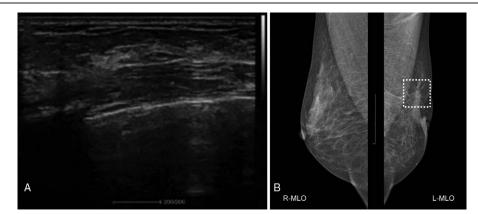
Radiography images of lymph nodes and breasts. (A) Ultrasonography examination of the lymph nodes and breasts did not reveal any abnormalities. (B) The mammography of the left breast (R-MLO) showed multiple abnormal signals compared with the normal one (L-MLO), which is considered adenomatous hyperplasia and multiple small mammary gland adenomas.
